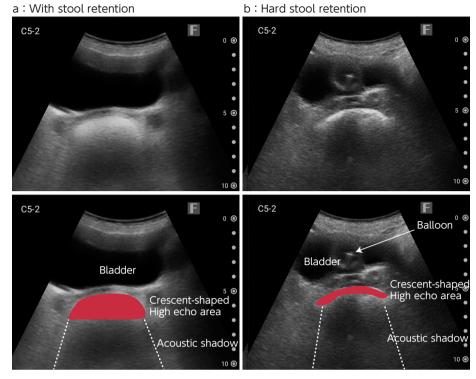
Ultrasound image (transverse view) of fecal impaction in the rectum
